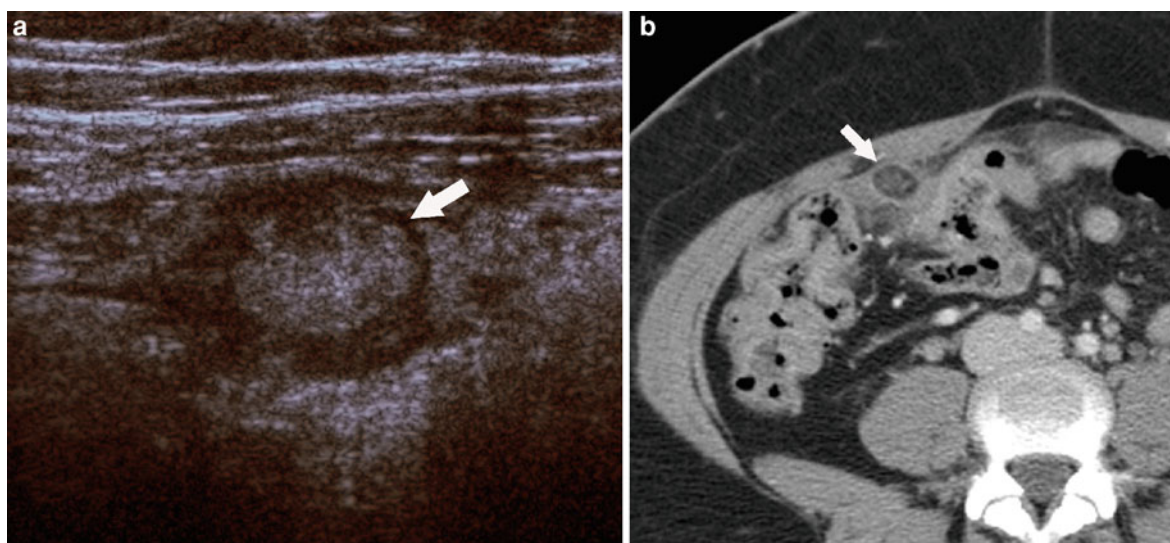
a, b Epiploic appendagitis mimicking appendicitis. a is sagittal sonogram of right lower quadrant demonstrating rounded discrete echogenic structure representing infarcted
